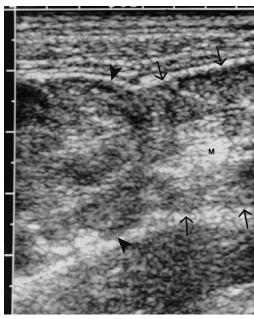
Sonogram in a 7.5-year-old boy shows a soft-tissue mass (*arrowheads*) at the apex of the intussusception (*arrows*). The mass has a nonspecific, heterogeneous echo appearance and represents the haemorrhagic, inverted Meckel diverticulum. (*M* mesenteric fat between layers of the intussusception)
